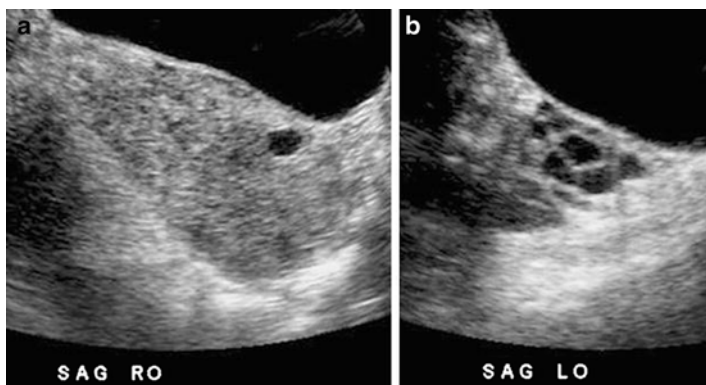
Ovarian torsion by ultrasound in a prepubertal girl (a) The torsed ovary is enlarged and heterogeneous and measures $7.9 \times 3.8 \times 6.3$ cm corresponding to a volume of 361.6 cm^3 . (b) The contralateral normal ovary measures $2.8 \times 1.4 \times 1.9$ cm corresponding to a volume of 14.2 cm^3 (Reprinted from Servaes et al. [41], Fig. 10.1, with kind permission from Springer Science and Business Media)
